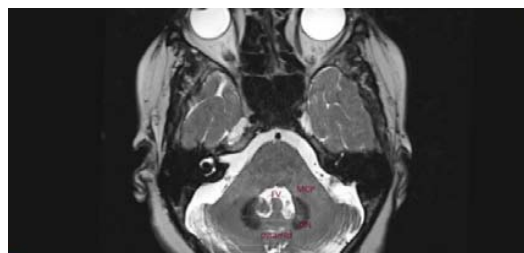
Axial view on the CISS 3D MRI showing the dentate nucleus seen as a hypo intense structure. FV (fourth ventricle), DN (dentate nucleus), MCP (middle cerebellar peduncle)
